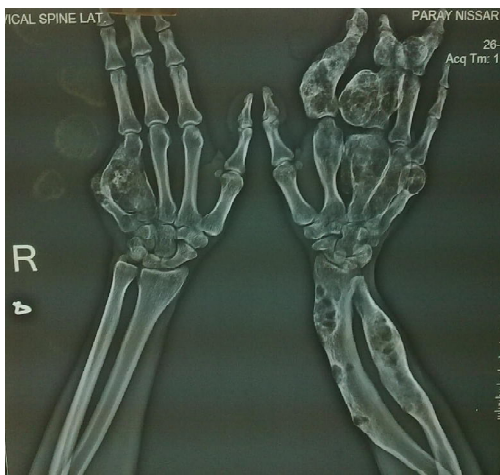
Radiograph of a 18 year old male showing Enchondromas.
